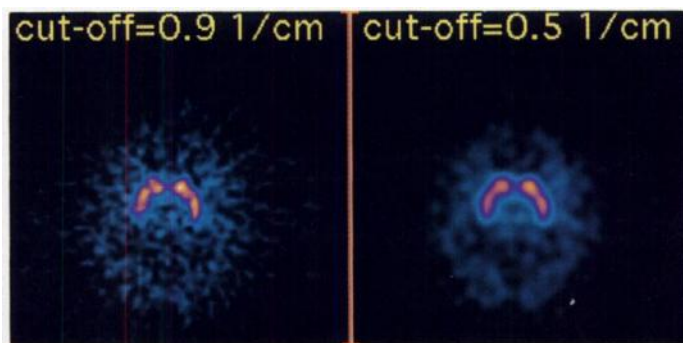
Transaxial slice of striatal [^{123}I] β -CIT uptake in a 37-yr-old healthy man using two cutoff SPECT filtering frequencies. The filter used was a Butterworth with an order of 8. There is a 30% difference in semiquantitation of (striatum-occipital)/occipital ratio between these two images.
